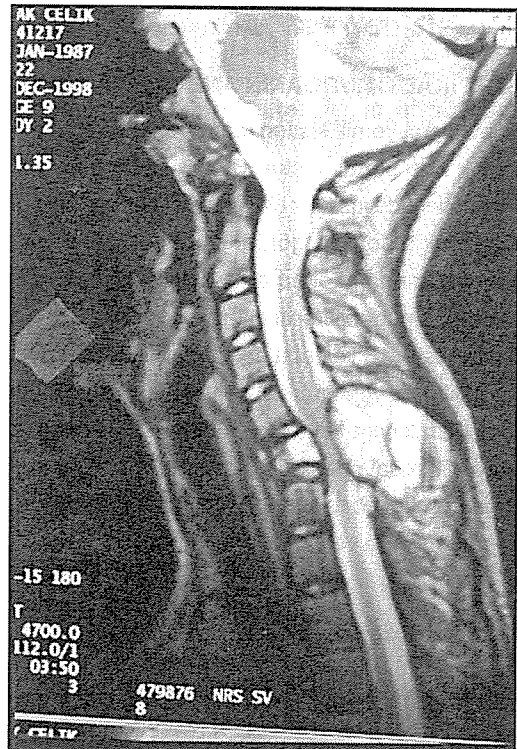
Sagittal MRI demonstrating the cystic trabecular nature of the aneurysmal bone cyst with compression of the spinal cord.
